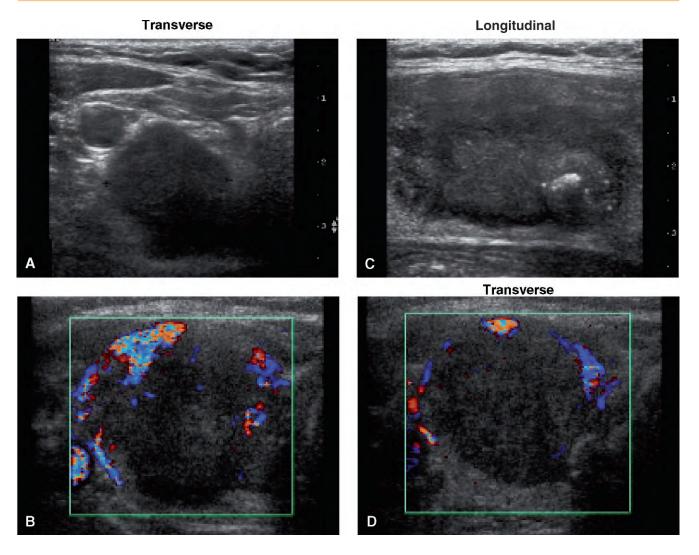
Ultrasound of medullary thyroid carcinoma in the right lobe. A, Transverse, 19 x 19 mm. B, Color Doppler, transverse. C, Longitudinal, sagittal diameter: 34 mm. D, Color Doppler, transverse.
